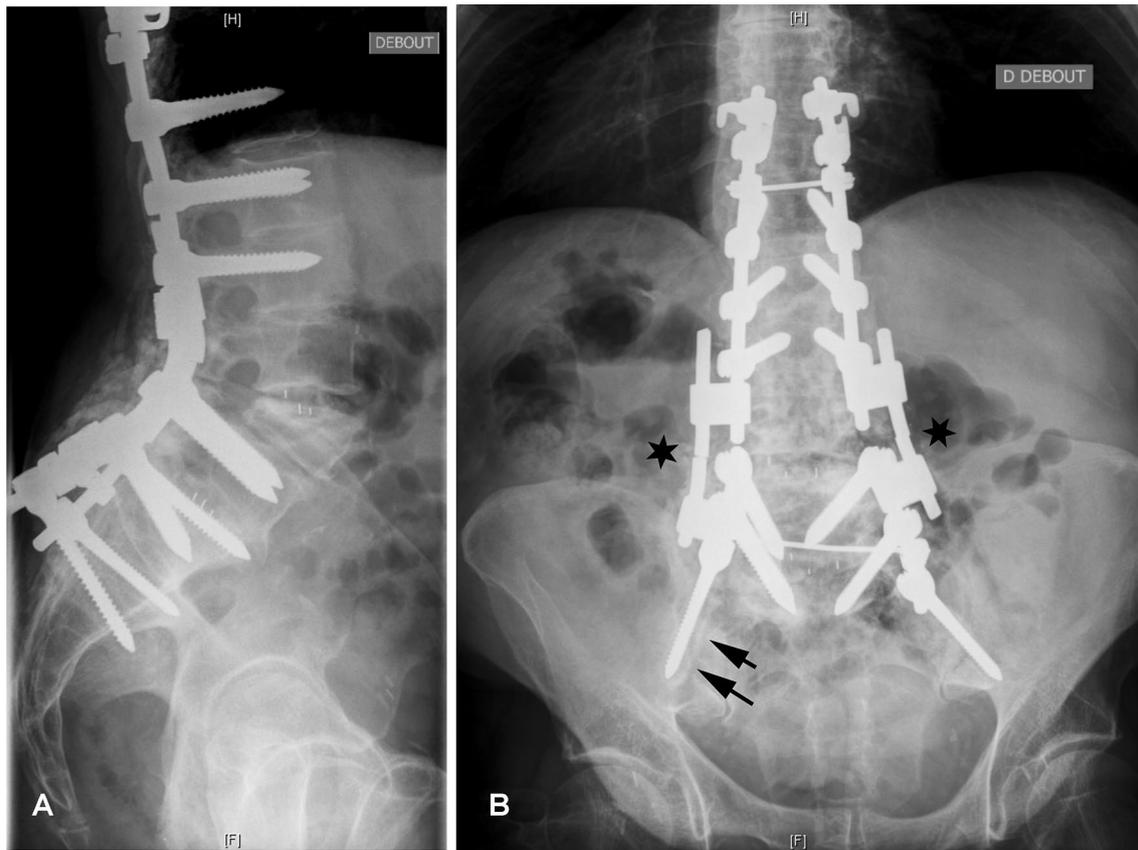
Five-year follow-up lateral (a) and posterior–anterior (b) radiographs of the same patient showing rod fractures (stars) suggesting pseudarthrosis and a halo (arrows) indicating S2-ala screw loosening
